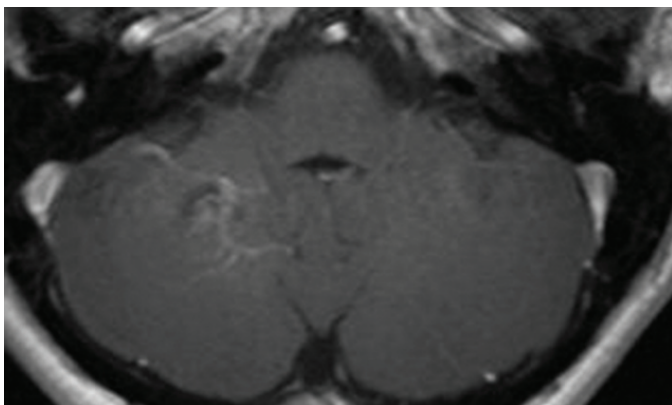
The axial contrast-enhanced T1-weighted image shows the venous angioma with its small dilated medullary veins distributed around and within the cavernous angioma that converge on a larger collector vein
